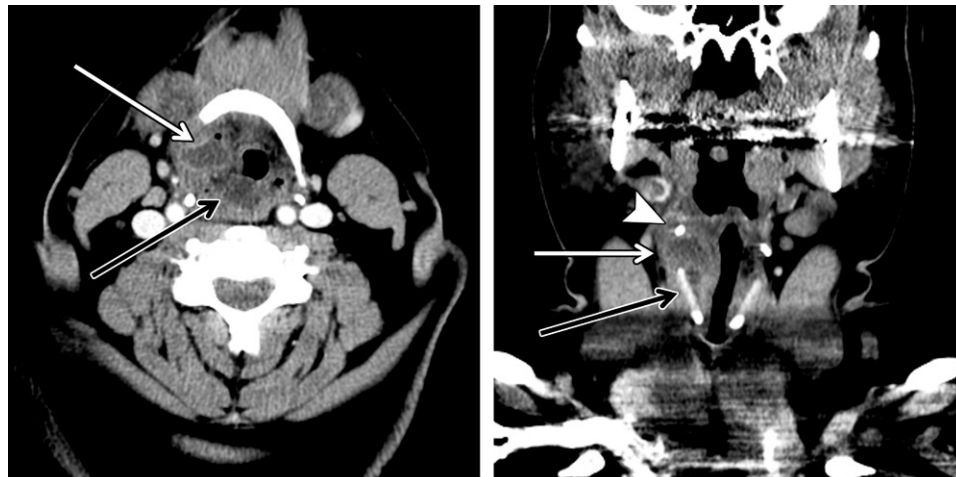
Pyolaryngocele in a 47-year-old woman with a severe sore throat, muffled voice, odynophagia, and stridor. Axial (a) and coronal (b) CT images show a rim-enhancing collection of fluid centered in the right paraglottic space (white arrow) in the expected region of the laryngeal sacculle near the thyrohyoid membrane between the hyoid bone (arrowhead in b) and the thyroid cartilage (black arrow in b), with adjacent soft-tissue stranding and inflammation extending to the right aryepiglottic fold and arytenoids (black arrow in a).
